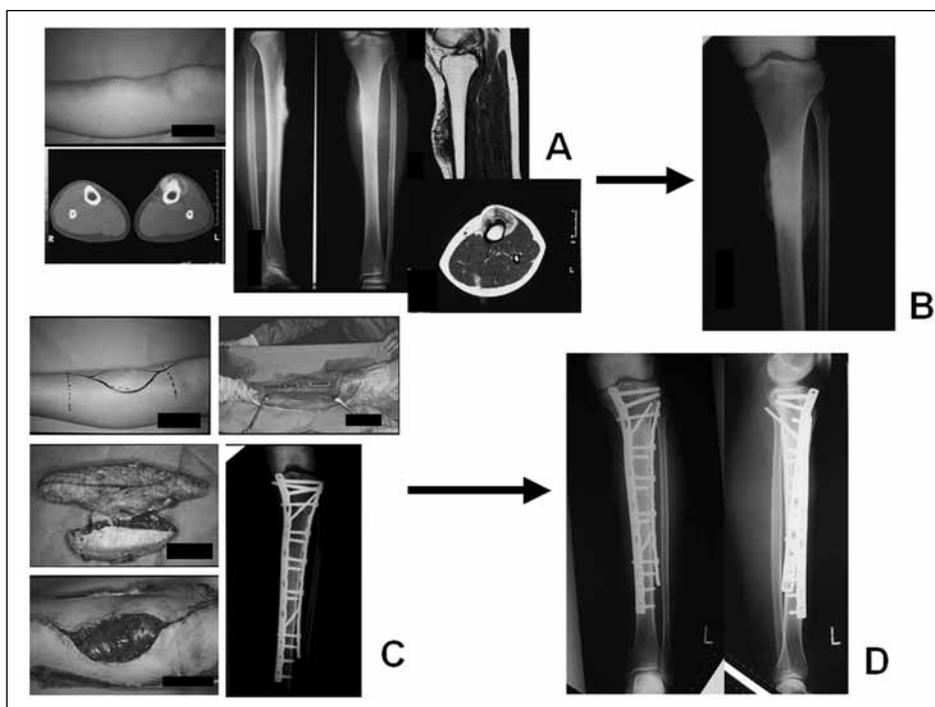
16-year-old girl with left-proximal tibial shaft periosteal osteosarcoma locally recurrent after resection elsewhere. A) preoperative macroscopic, plain X-ray, CT, and MRI findings, B) plain X-ray after preoperative chemotherapy, showing sclerotic change of extraosseous lesion, C) intercalary IORBG with dual-plate fixation + gastrocnemius muscle flap reconstruction, D) plain X-ray 12 years postoperatively shows complete bony union at both IORBG-host bone junctions.
